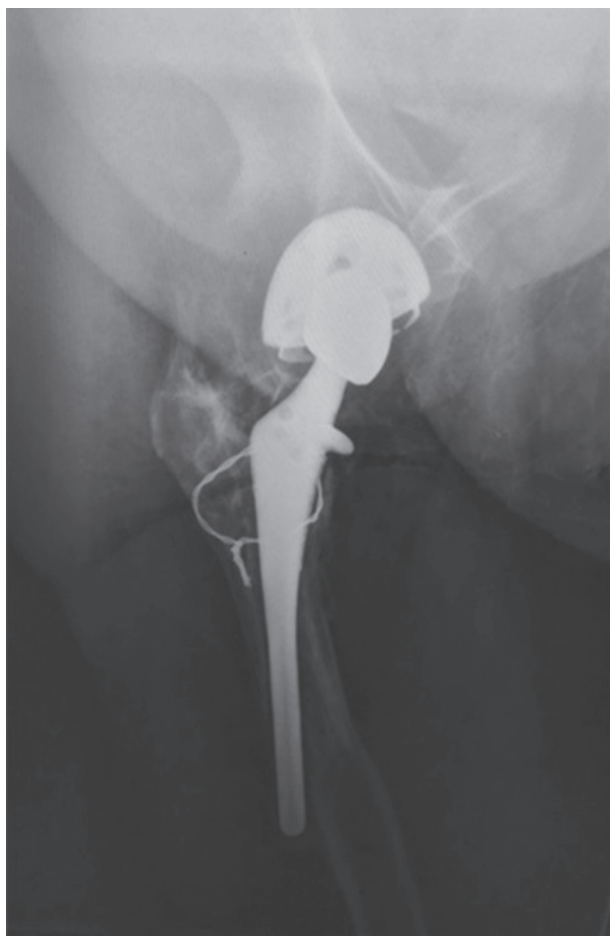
Lateral radiograph of the left hip and proximal femur showing a B2 type periprosthetic fracture. The stem is loose but there is adequate bone stock.
